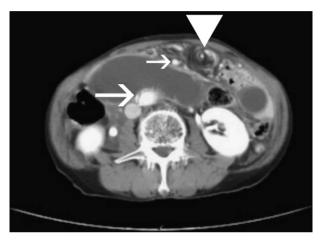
Abdominal computed tomography (CT) scan showing the dilated afferent loop between the small arrow (SMA) and aorta (large arrow). CT also shows anterior displacement of SMA and that none of the contrasting agent passed into the afferent loop. A "whirl" formation (arrowhead) may have lead to the obstruction of the afferent loop. No oral contrasting agent was found in the afferent loop.
